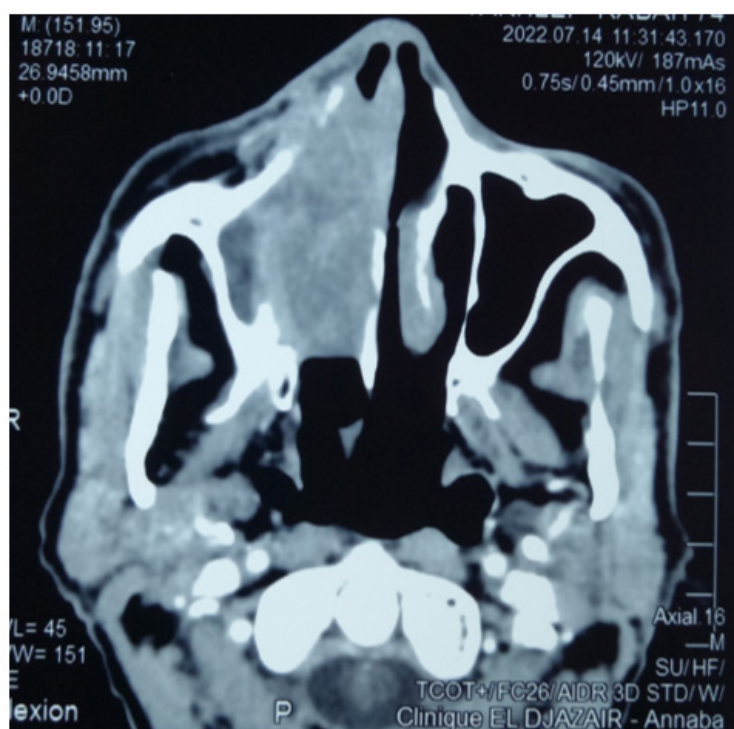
Axial CT scan showing an aggressive tumor of the right maxillary sinus with bony destruction of the anterior wall.
